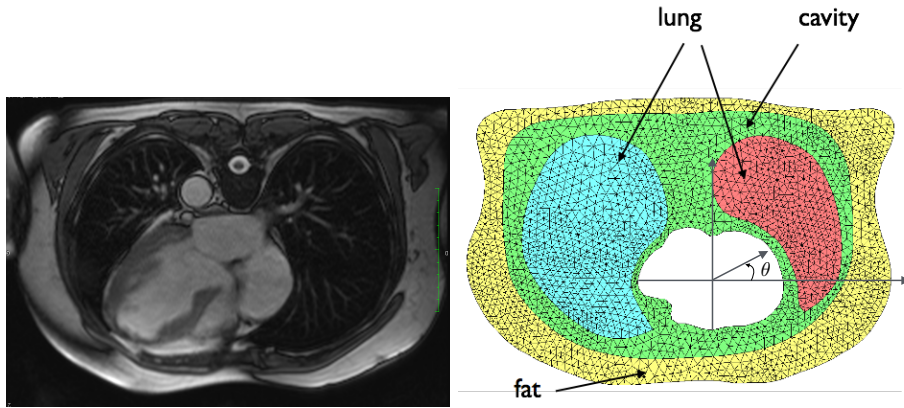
MRI 2D slice of the torso (left), 2D computational mesh of the torso geometry showing the different regions of the torso considered in this study : fat, lungs and torso cavity, (right). The angle θ is the second polar coordinate.
